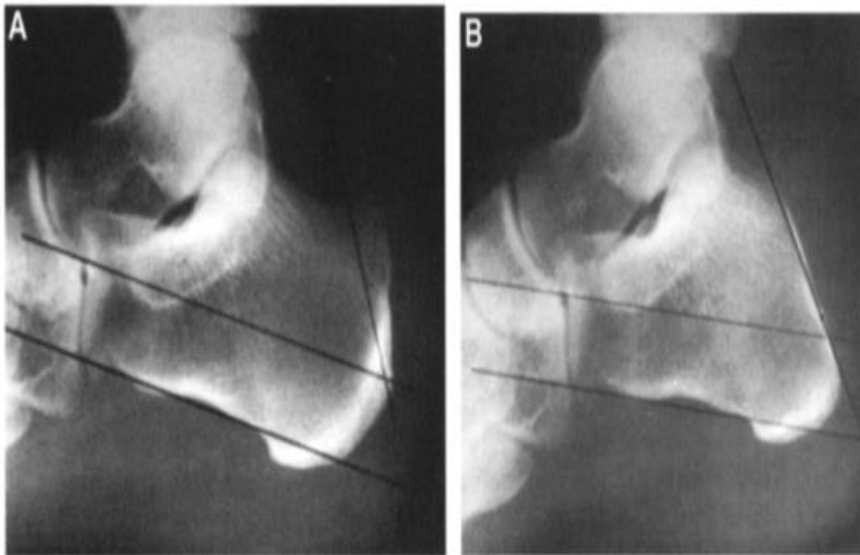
Preoperative (A) and postoperative (B) radiographs showing the amount of bone removed. (14)
